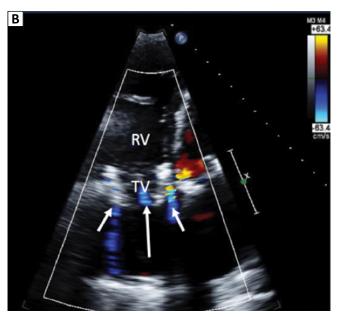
Panel A*. Post-deployment of additional Amplatzer vascular plugs to treat worsening lateral paravalvular leak (PVL) in addition to medial plugs from initial catheterization. *Panel B*. Transthoracic echocardiogram with Doppler post-deployment of additional vascular plugs showed reduced PVL. Trace central regurgitation was noted. RV = right ventricular; TV = tricuspid valve.
